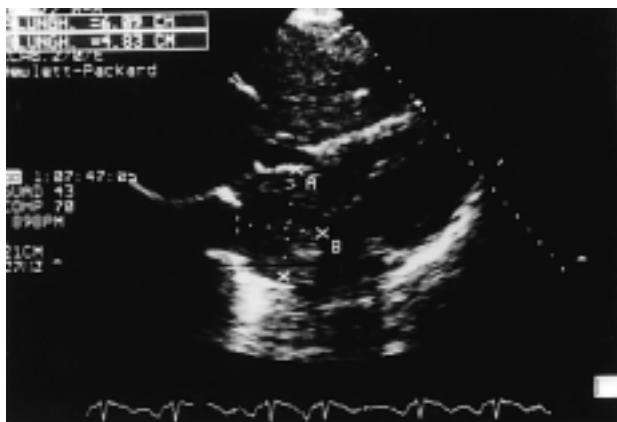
Two-dimensional transthoracic echocardiogram: subcostal view.
